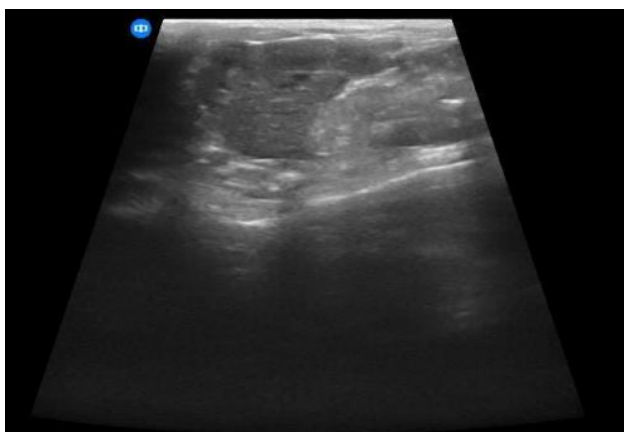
The image of ultrasound in healthy (A) and fatty liver group (B).
